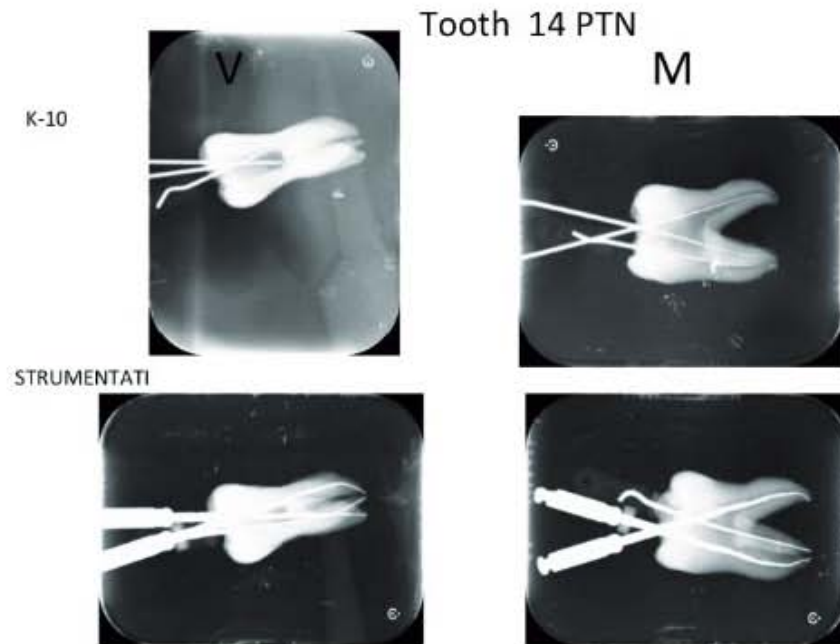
Pre- and postoperative radiographs of a molar treated with PT instruments.
